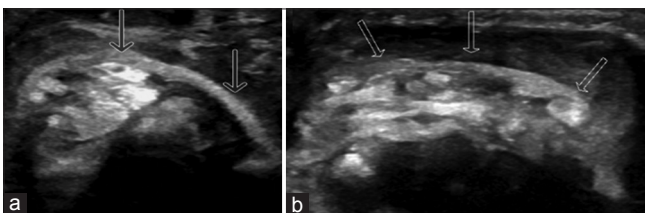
Ultrasonography (USG) appearance of rubber band at the level of the proximal crease of the wrist joint. Transverse USG of the volar aspect of the wrist joint (a) shows circumferential linear echogenic foreign body (arrows) deep to the flexor retinaculum between the flexor digitorum profundus and digitorum superficialis tendons, which represents the rubber band. Transverse USG of the dorsal aspect of the wrist joint (b) shows circumferential linear echogenic foreign body (arrows) deep to the extensor retinaculum and superficial to extensor tendons, which also represents rubber band.
